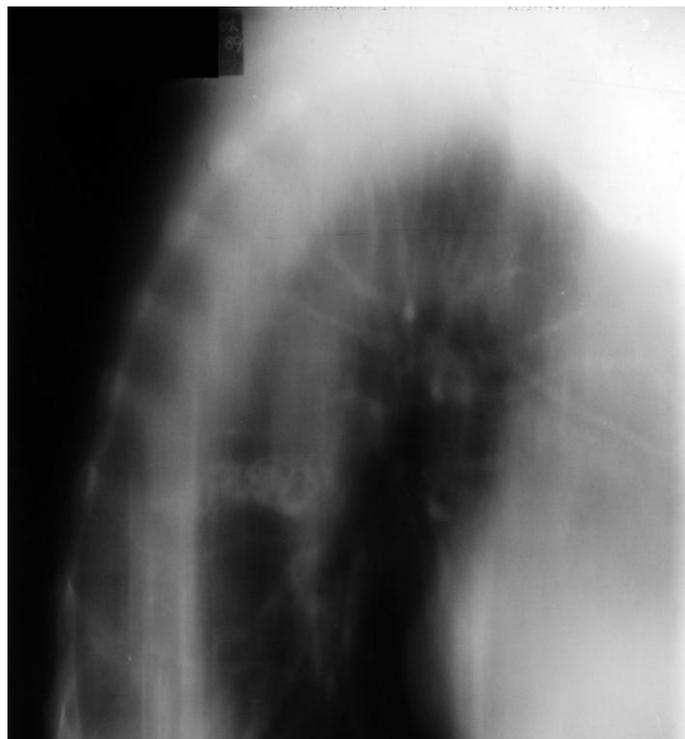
66 year old female with chronic pulmonary aspergillosis. October 1990 Computed tomogram of thorax showing early cavitation and adjacent inflammatory reaction in the apical segment left lower lobe. The surrounding lung parenchyma appears normal.
